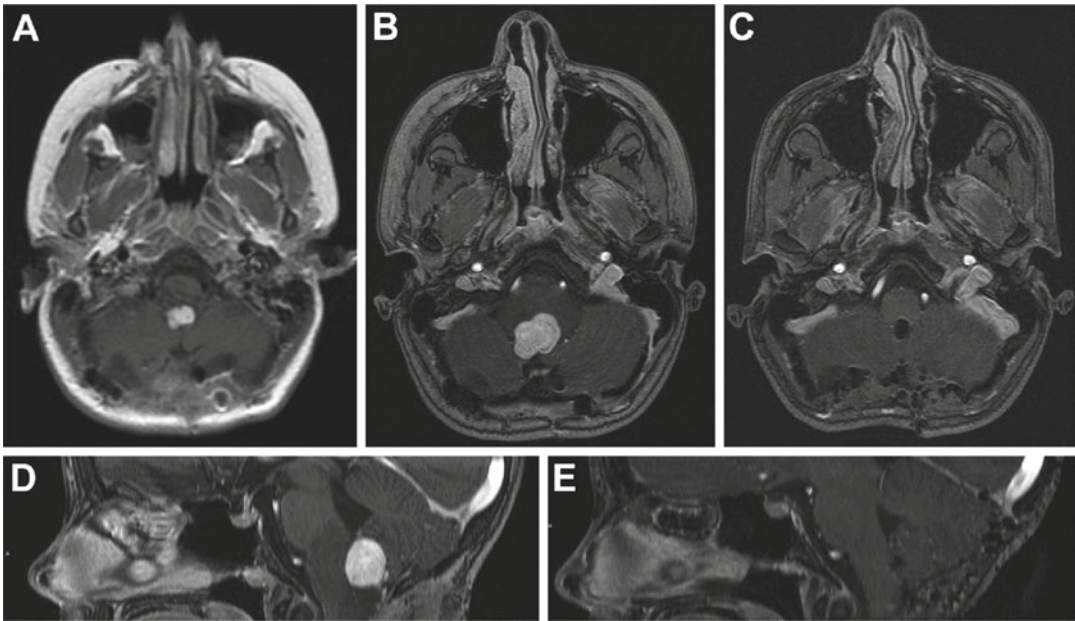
Pre-operative (a, b, d) and post-operative (c, e) T1-weighted magnetic resonance imaging with contrast revealing an obex hemangioblastoma. The obex hemangioblastoma can be seen to obstruct the fourth
